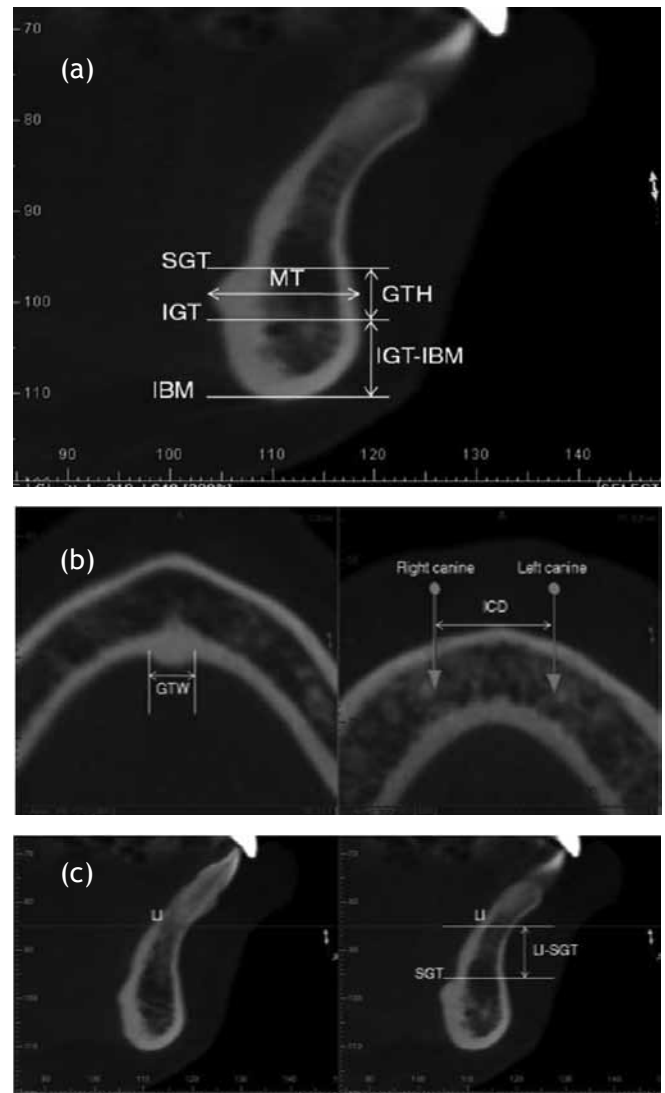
Cone-beam CT scan showing various measurements (a) MT, GTH and IGT-IBM, (b) LI-SGT (c) GTW and ICD
